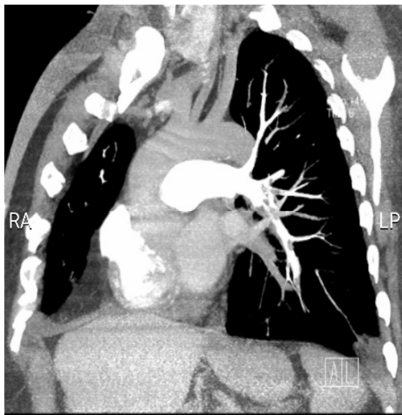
CT Angiography of pulmonary artery showing filling defect in RLL, LLL and RML artery suggests pulmonary thromboembolism.
